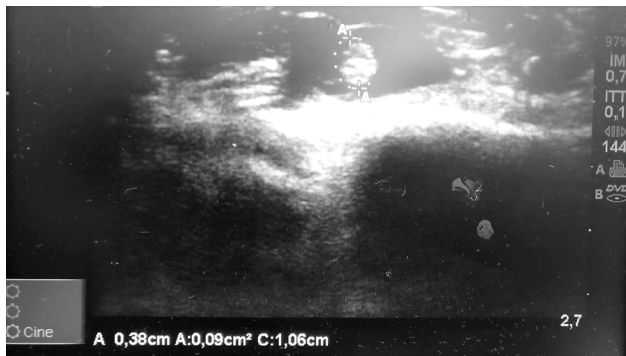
Ultrasound study. Patient non affected by carpal tunnel syndrome.
